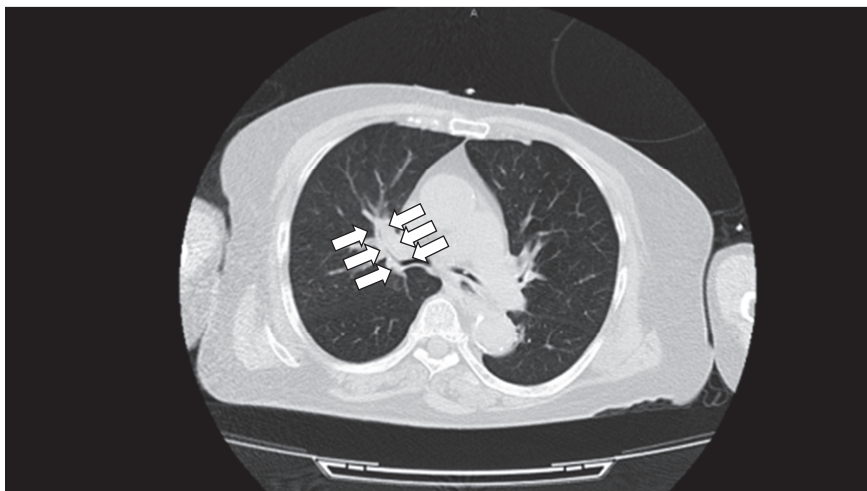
Chest CT: Thickening of the tracheal wall was observed (white arrow).
